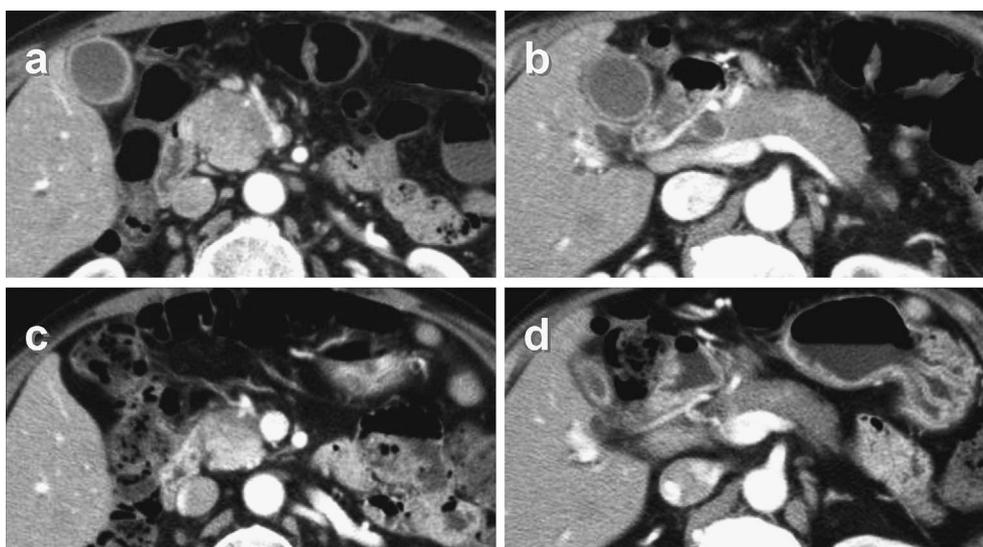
Case 1. On admission, abdominal computed tomography with intravenous contrast reveals diffuse pancreatic enlargement (a and b). Following steroid therapy, the pancreatic swelling is markedly improved (c and d).
